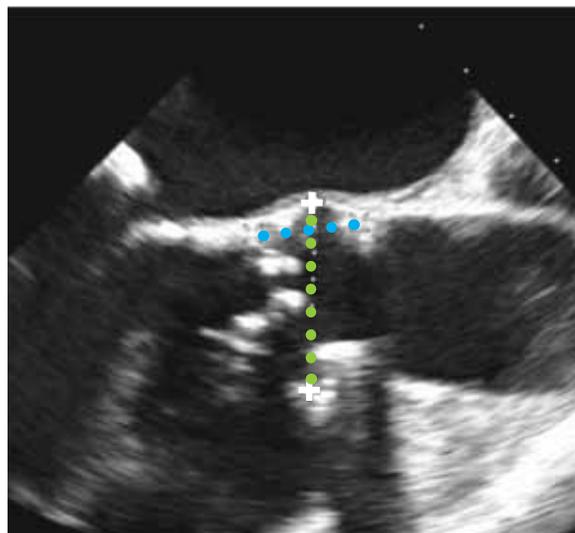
The standard “three-chamber” transesophageal echocardiogram (TEE) view is used to assess aortic valve calcification, leaflet mobility, and root dimensions. Much like CTA (Figure 11), TEE is used to measure sinotubular junction height (blue line) and aortic root diameter at the sinus of Valsalva (green line).
